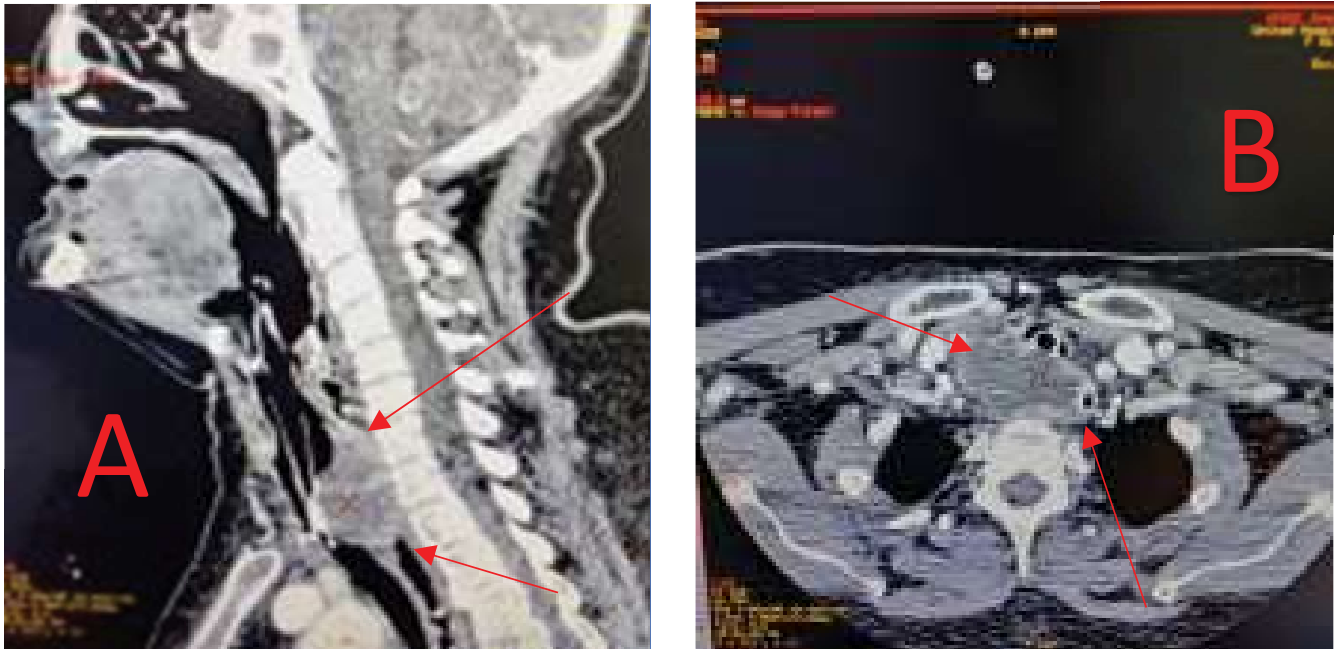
CT scan of Neck shows a mixed density mass compressing the trachea from back with almost complete occlusion of the airway and partial obstruction of the esophagus [Panel A - Lateral view, Panel B- Axial view]
